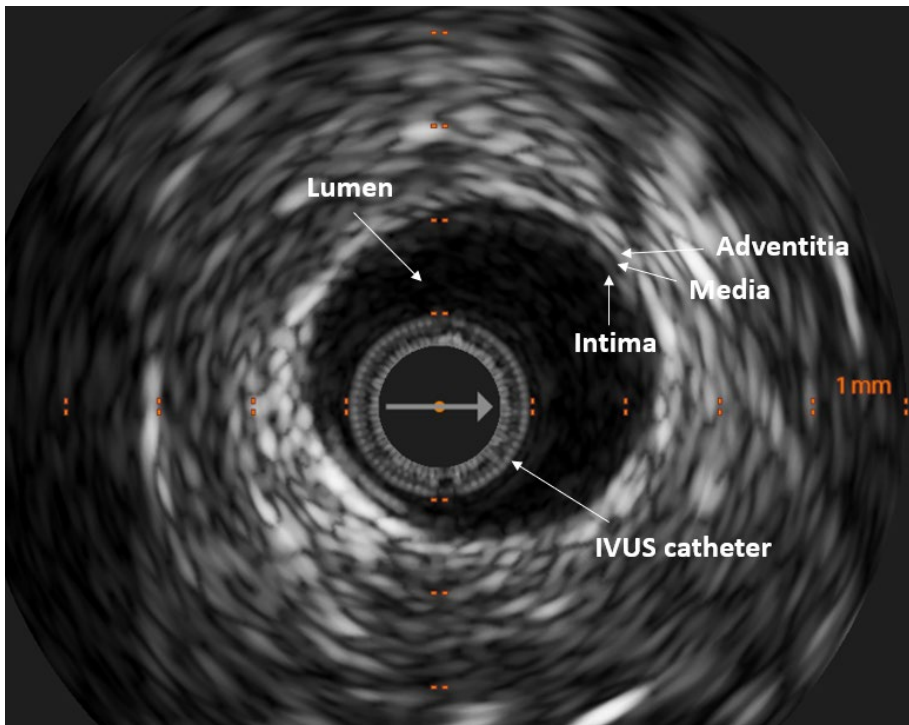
Intravascular ultrasound image demonstrating a normal segment of the coronary artery.
